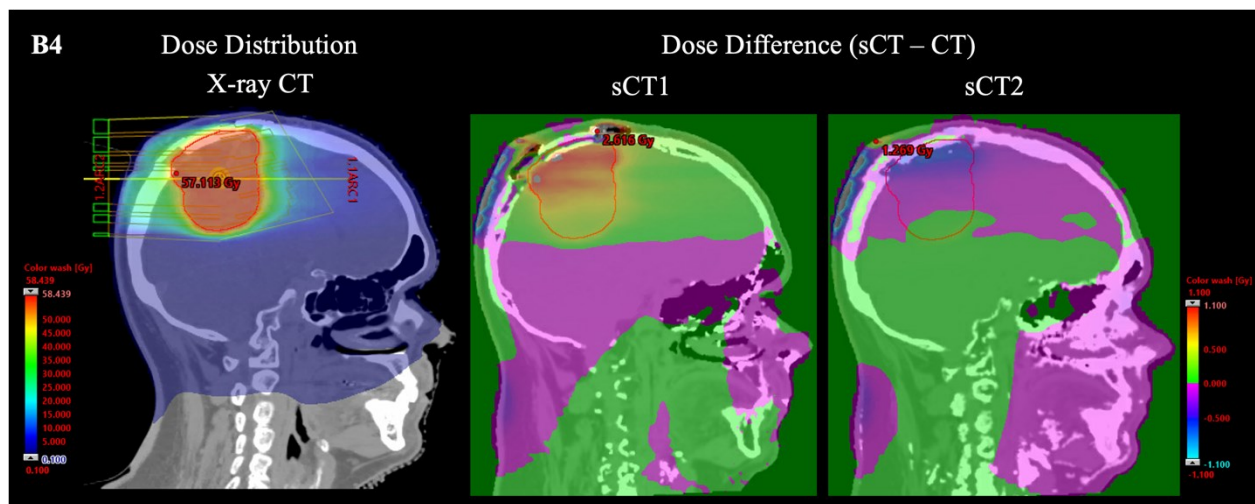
Dose distribution calculated on the planning CT image and dose difference maps for sCT1 and sCT2, as compared to the dose distribution on CT, for patient B4. Metal artifact due to Ti implants in MRI caused an enlarged volume of Ti implants in sCT2.
